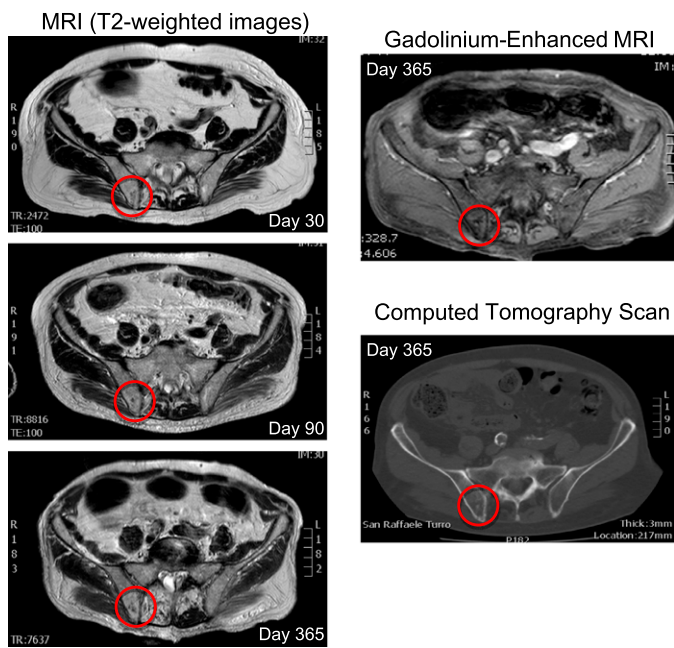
MRI and computed tomography scan of iliac BM. MRI T2-weighted images acquired 30 and 90 days and 1 year after islet transplantation in patient 3 (left). A small hypointense area (red circle) inside the normal hyperintense signal was evident at the site of the islet infusion at the level of the posterior-superior iliac spine. The gadolinium-enhanced MR perfusion study did not show areas of anomalous enhancement surrounding the site of the islets infusion (right). A computed tomography scan showed the presence of a small calcified spot at the site of islet infusion (lower right).
